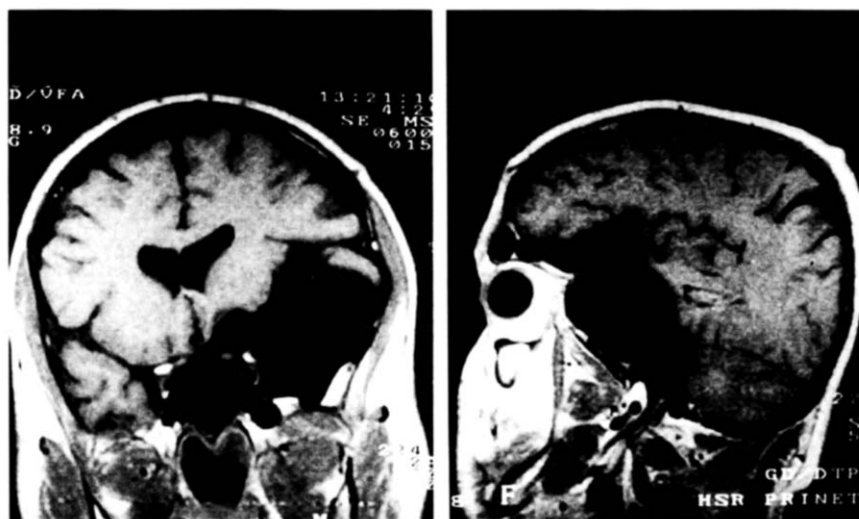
T1-weighted coronal MRI (left side) and T1-weighted sagittal MRI after gadolinium administration (right side) revealed a voluminous cyst arachnoidea compressing the left frontal and temporal lobes.
